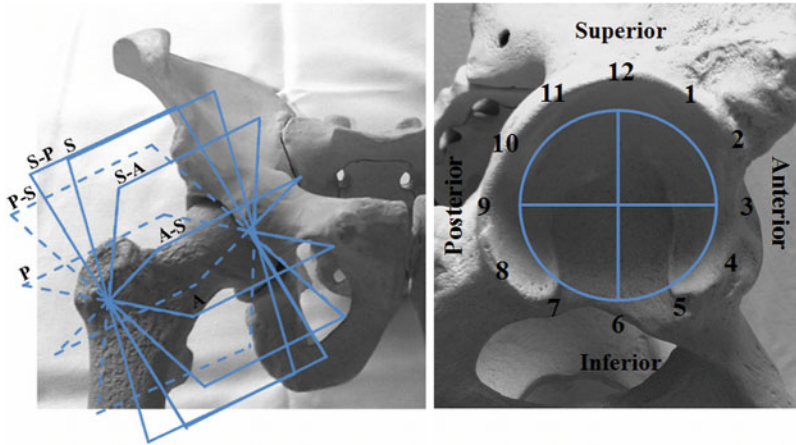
2D or 3D radial imaging with (MRA) and without contrast-enhancement (MRI) is a standard approach to evaluate the hip because it minimizes volume averaging by displaying the joint in perpendicular sections around the entire circumference whereas anatomy and potential abnormalities of femur, acetabulum, and labrum are optimally visualized. Furthermore, it
